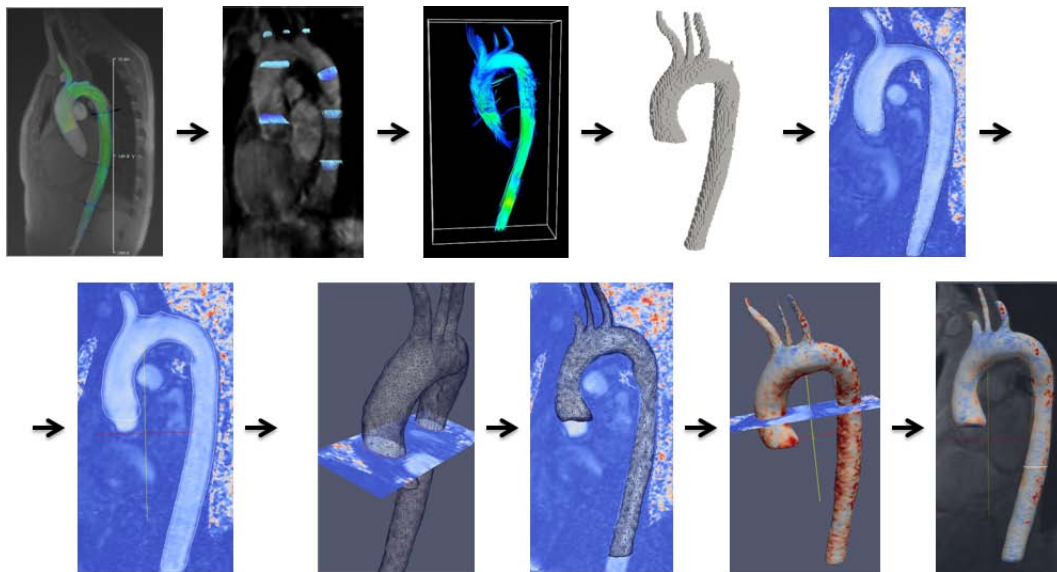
Preliminary concept of automatic segmentation of the Aorta based on 4D MRI data
